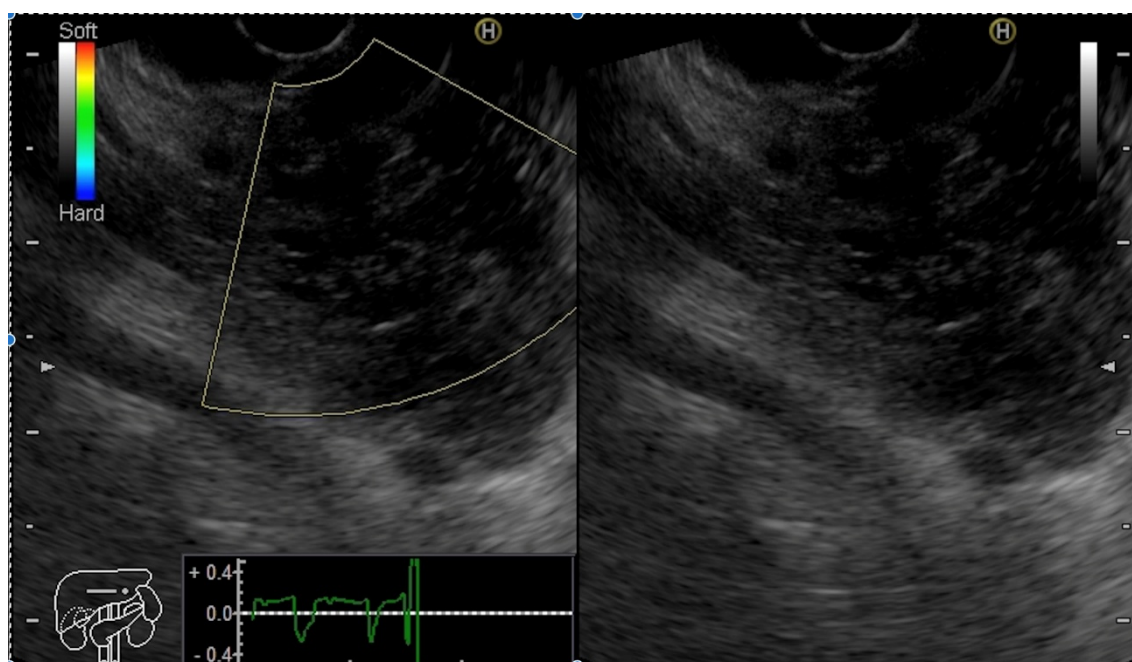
Linear endoscopic ultrasound (EUS) (Pentax EUS J-10) revealed a 50 x 45 mm sized, hypoechoic, heterogeneous, well-defined round mass in the pancreatic body with anechoic areas and some calcifications.
